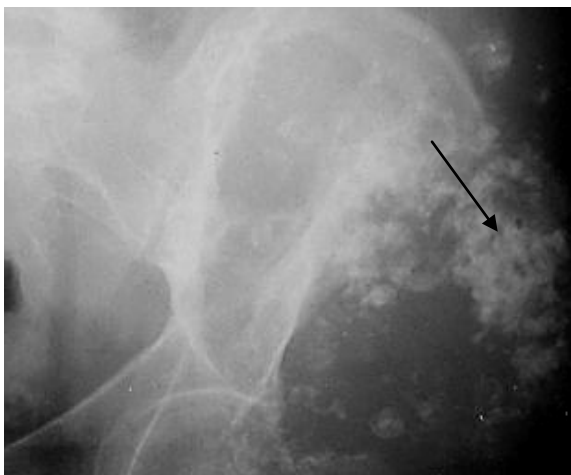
Radiograph of the pelvis in a direct projection. In the area of the iliac bone there is an extensive destruction zone with indistinct contours, involving the cortical layer, pathological bone tissue with non-homogenous structure (arrow). Chondrosarcoma of the left iliac bone is detected
